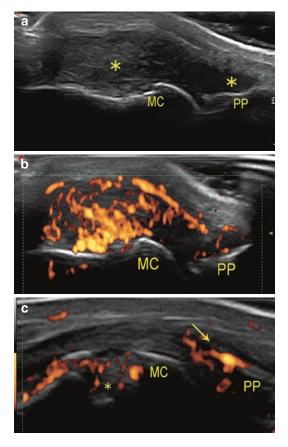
(a) Marked synovial thickening (*asterisk*) at MCP joint; (b) marked power Doppler signal representing synovial vascularity (*red*) and (c) active erosion with power Doppler signal in the bottom of a break in the cortex (*asterisk*). Power Doppler signal in an area of synovial thickening (*arrow*)
